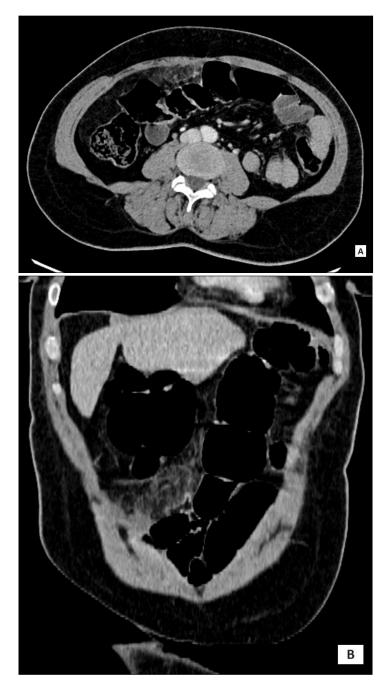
Abdominal CT scan, axial (A), sagittal (B) and coronal (C) sections, showing infiltration of the greater omentum creating a pseudo-mass.
